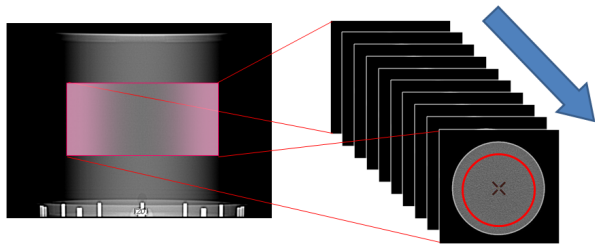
Thirty percent from the central among the reconstructed image data in 1 bed acquisition set as 'Valid Image Range' and measured SUV.
